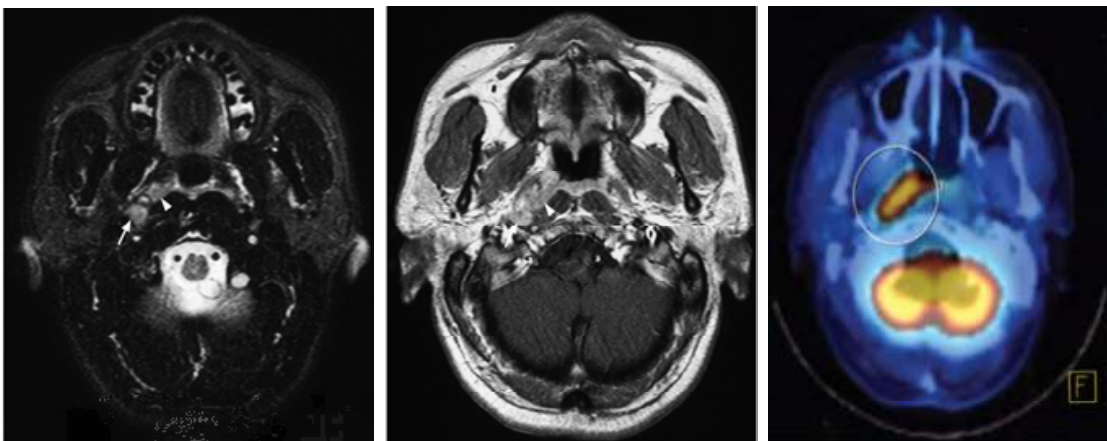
CT scan (left, middle) and PET scans (right). PET scans can discover tumors areas that appear normal on CT scan but have significantly increased metabolic activity
